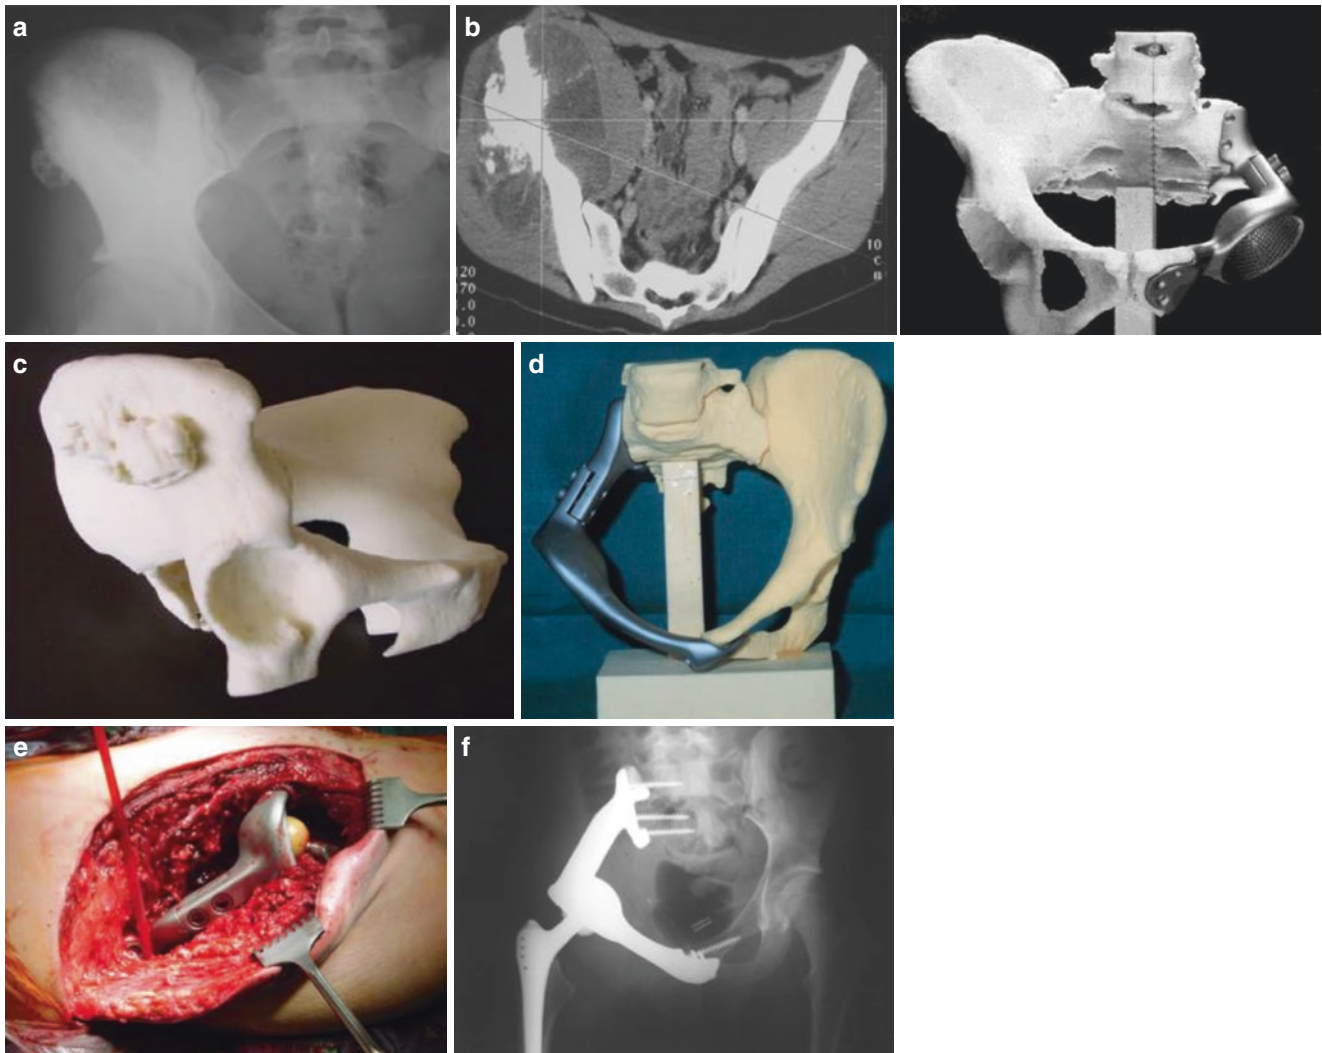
The custom-made pelvic endoprosthesis by CAD approach. The planned resection area and custom-made endoprosthesis was fixed on the pelvic saw bone. The intraoperative photo and postoperative x-ray was shown. (Copyright © Wolters Kluwer Health | Lippincott Williams & Wilkins)
